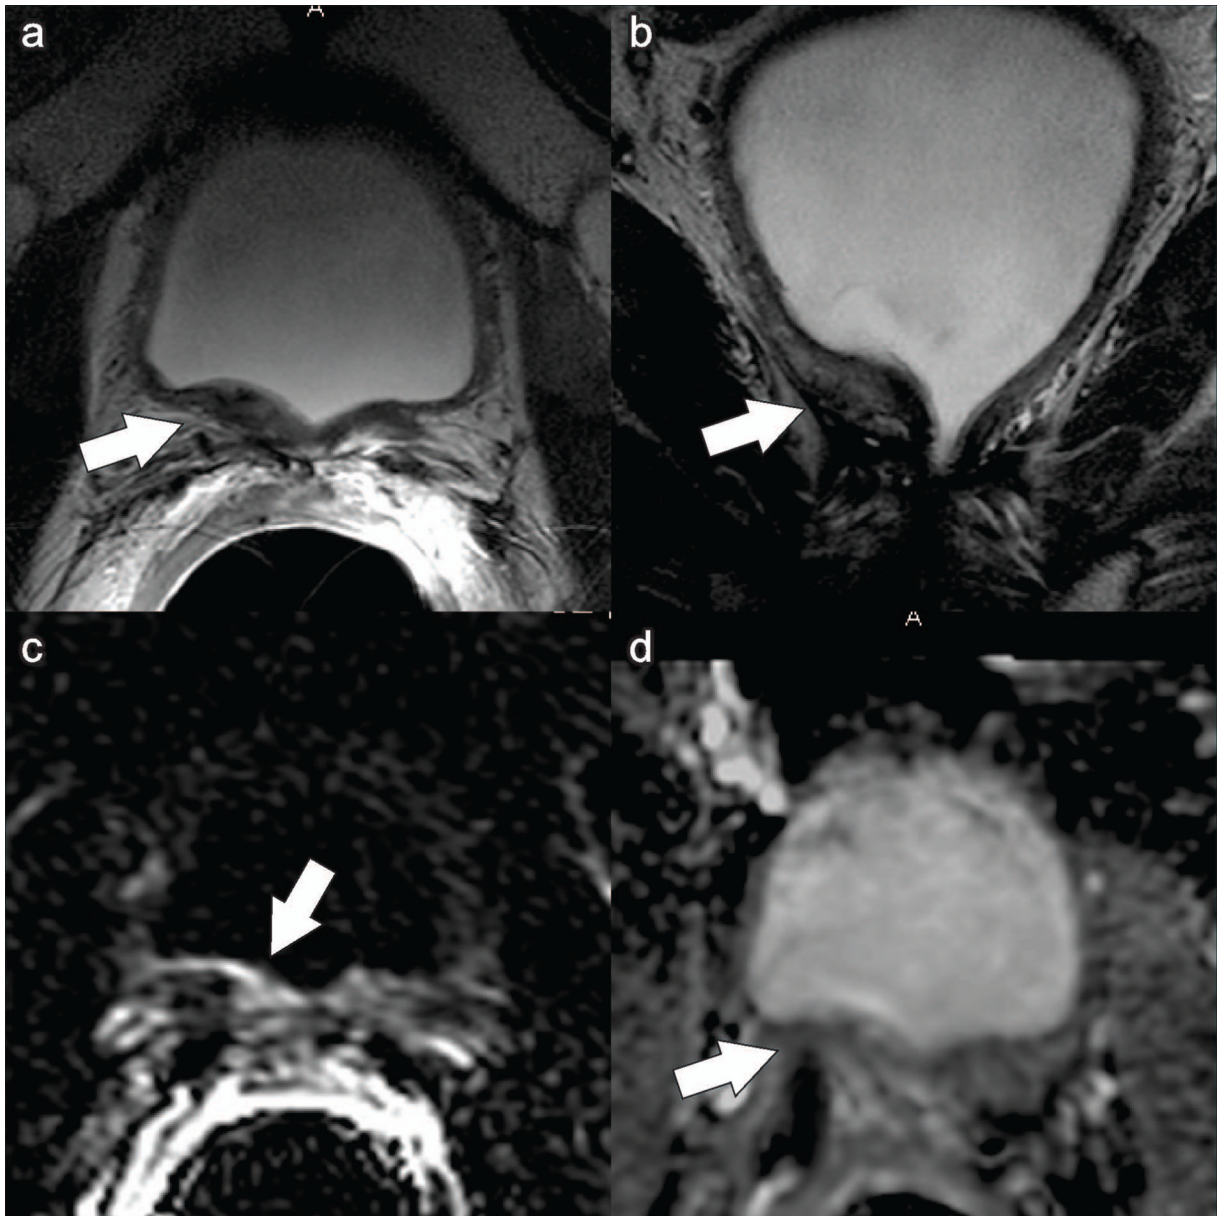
Multiparametric prostate MRI (a: axial T2W, b: sagittal T2W, c: DCE subtraction, d: ADC map (b=500)) of a 60 year old patient with biopsy-proven prostate cancer (Gleason 4+3=7) and rapidly rising PSA. The MRI shows signal abnormalities in the medial part of the seminal vesicle suggestive for seminal vesicle invasion (arrows).
